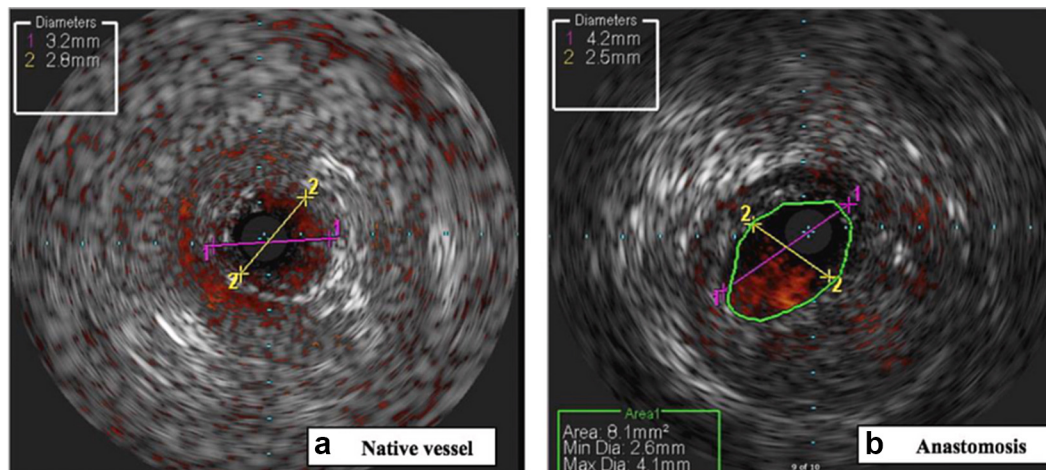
Intravascular ultrasound (IVUS) images demonstrating the native vessel (a) and the anastomosis from prior reimplantation surgery (b).
